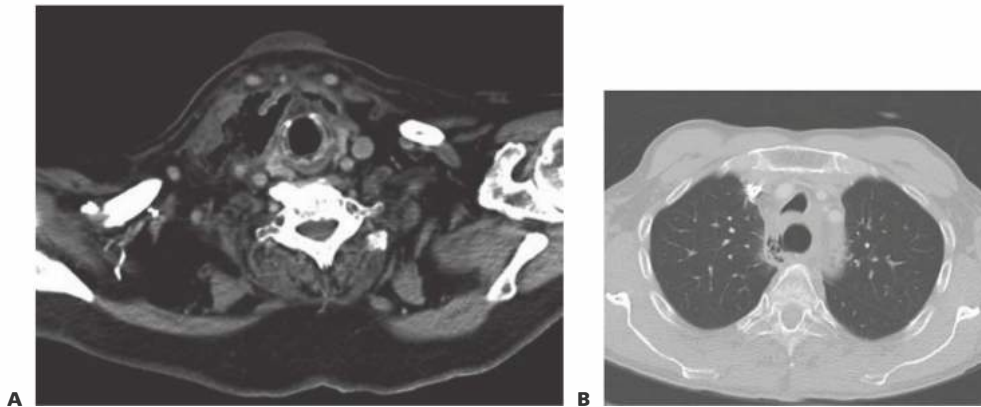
• A. CT scan showing subcutaneous emphysema in the neck following cervical esophageal perforation. B. CT scan showing pneumomediastinum.
